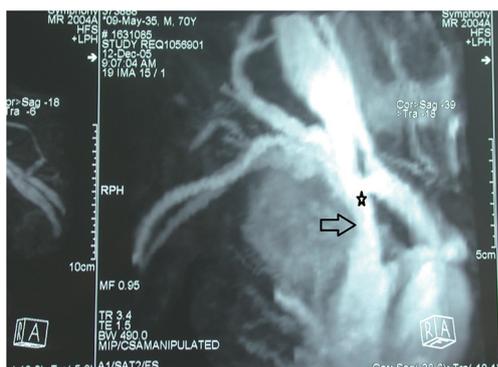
MRI of superior vena cava involvement. Harrow: tumor infiltrating the vessel (star). MRI, magnetic resonance imaging.
